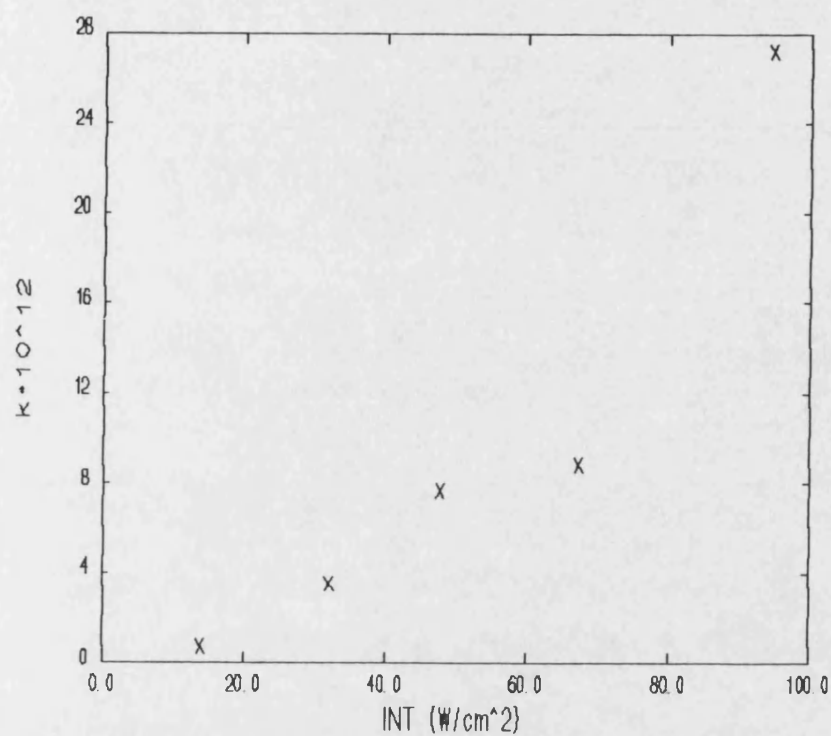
Effect of ultrasonic intensity on the Schmid rate constant
